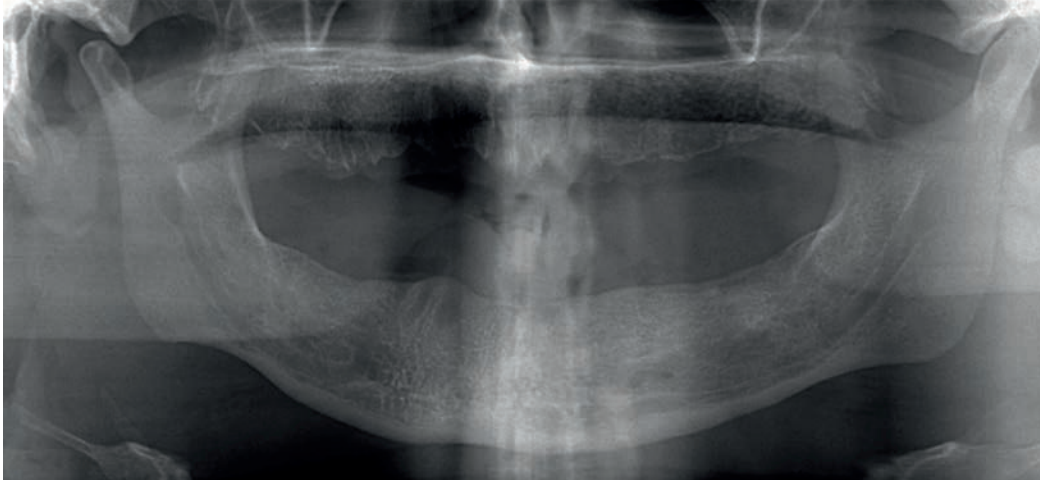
Radiographic presentation after full mouth extraction
